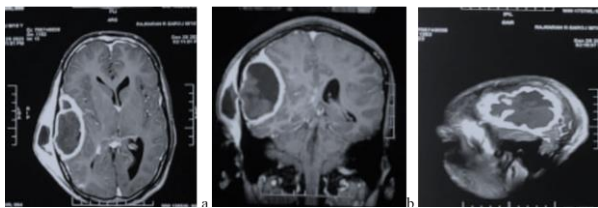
A, B and C shows rim enhancing lesion on MRI contrast films in axial, coronal and saggital sections respectively
